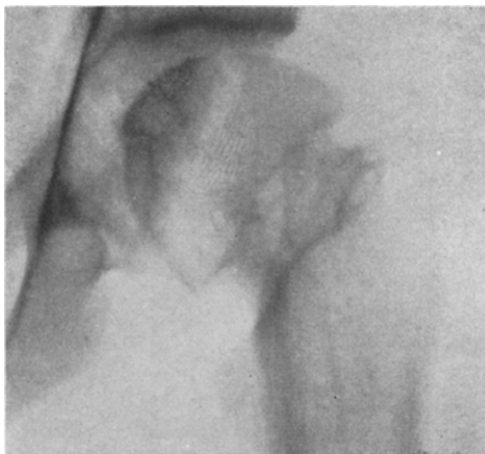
Case XIII. Roentgenogram five years after drilling, February 3, 1937; firm union, fairly well shaped head; primary focus in head still persisting.
